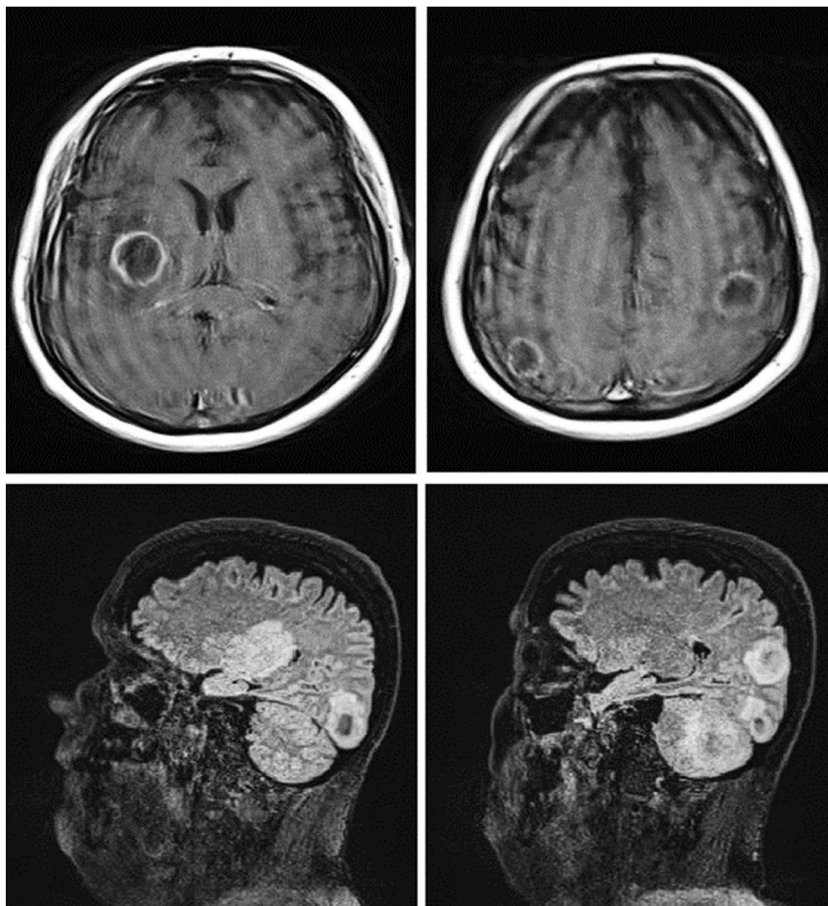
MRI showing multiple intracranial expansive formations with grossly round shape, consisting of a central portion and rim enhancing with contrast medium. All lesions appear surrounded by edema. Larger lesions are located in: a,b) bilaterally in the temporal and parietal lobes; c,d) the occipital region and left cerebellar hemisphere (resulting in mass effect on the fourth ventricle).
